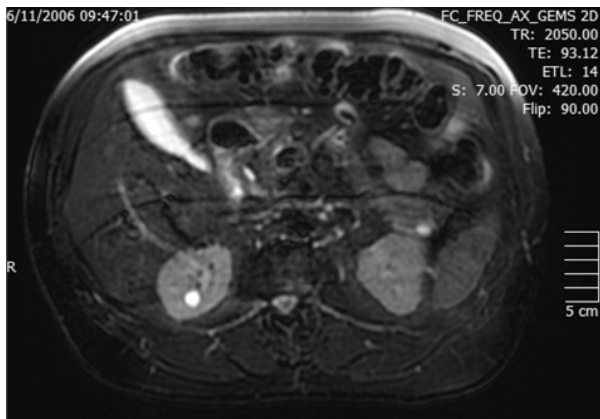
MRI view of the lymphoepithelial cyst tumor.
